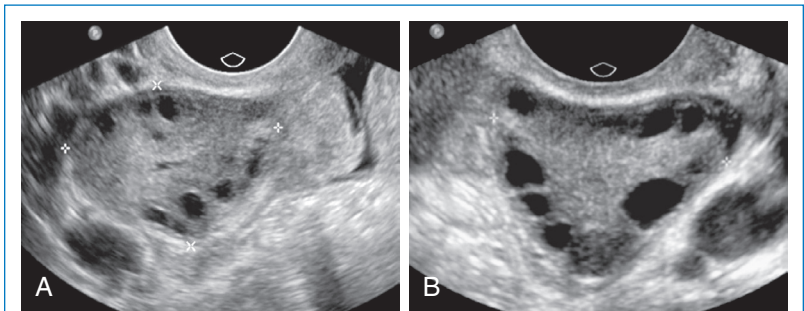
Polycystic ovaries. Sagittal (A) and transverse (B) transvaginal ultrasound of the left ovary depicting enlarged ovaries with multiple subcentimeter peripherally placed follicles and echogenic central stroma. (From Adam A, et al. Grainger and Allison's diagnostic radiology. 5th ed. Edinburgh: Churchill Livingstone, 2008, Fig. 54-22.)
